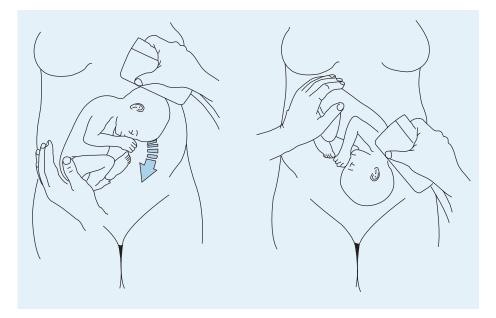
Method of using ultrasound transducer to guide vertex into pelvis. (Reprinted with permission from reference 39)
